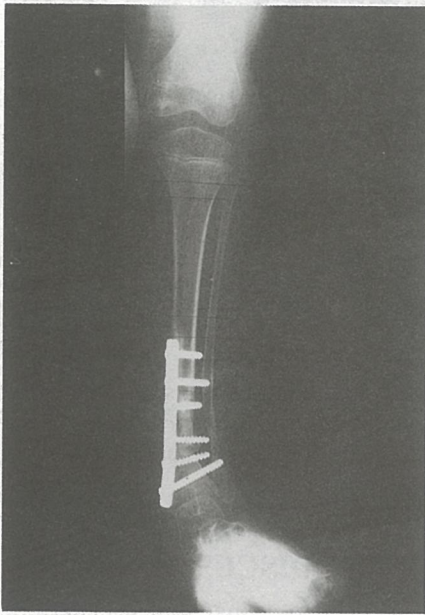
The radiograph showing failure to achieve union of congenital pseudarthrosis of the tibia after plating.
